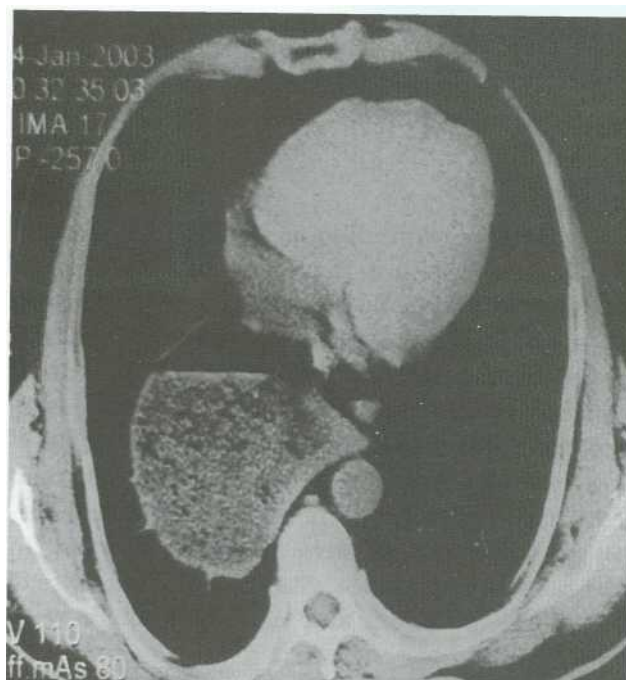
Computed tomography: Mass filled with solid and gas in the chest
